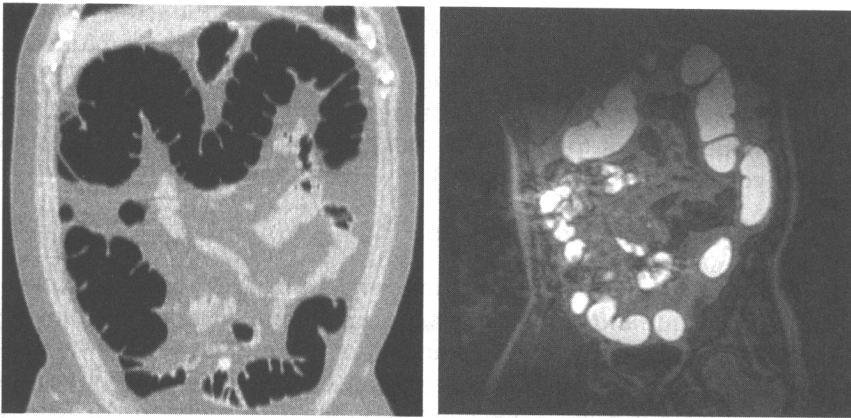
Shown are images acquired with CT (left) and MRI (right; from Vos et al., 2001, reprinted by permission of the Radiological Society of North America).
